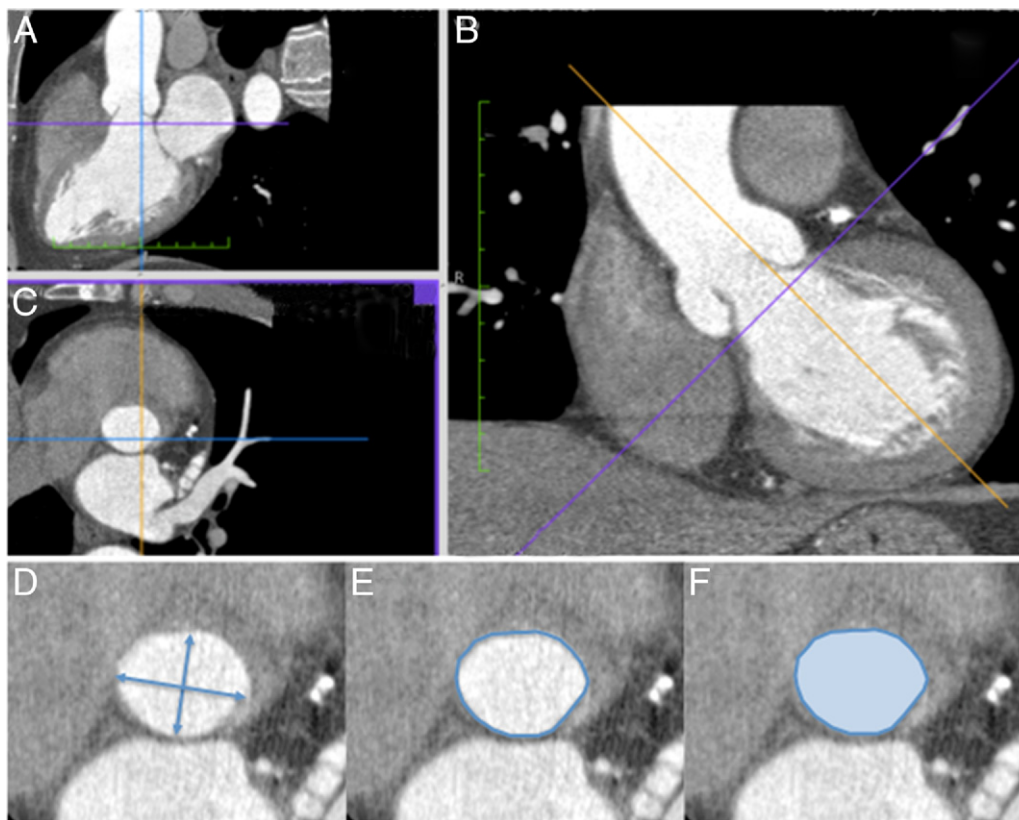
Reconstruction of the Aortic Annulus by Computed Tomography
